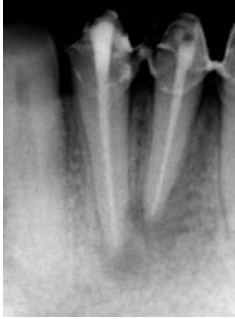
Intra oral periapical radiograph shows periapical lesions in both teeth two years after endodontic therapy
